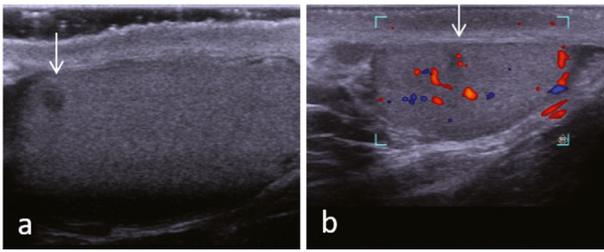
Ultrasound images of an incidentally detected testicular Leydig cell tumour (*arrows*) in a patient diagnosed with infertility. (a) B-Mode longitudinal projection reveals a hypo-echoic, well-defined lesion 3 mm in diameter. (b) Color Doppler imaging transversal projection reveals that the vascularity of the lesion is sparse and located peripherally.
